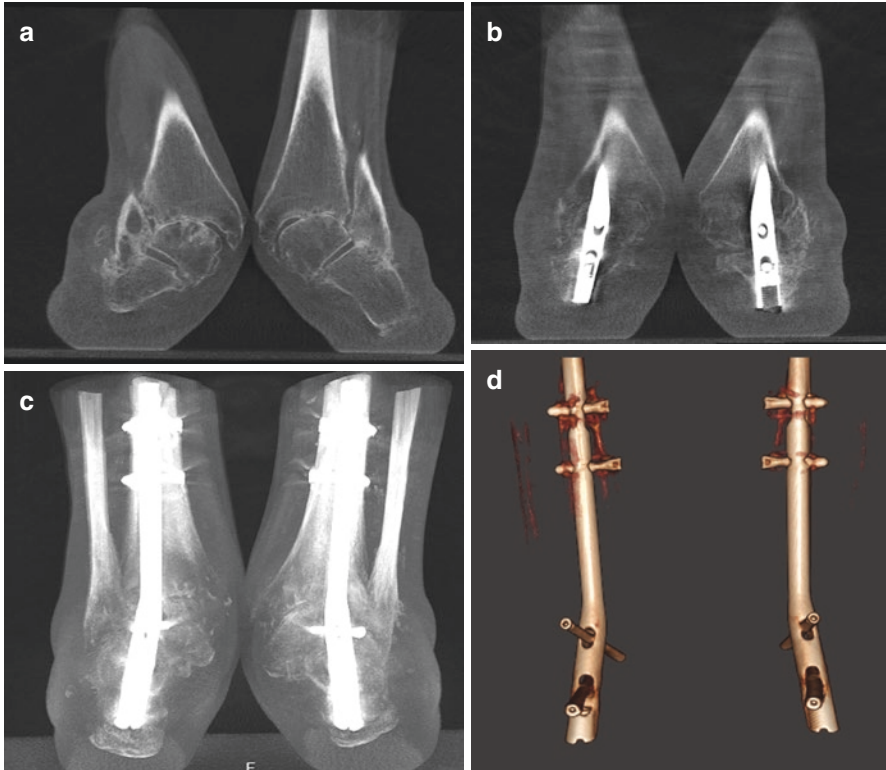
(a–d) Charcot arthropathy at the hindfoot (Localization Sanders IV) before (a) and after bilateral hindfoot correction arthrodesis (b–d). The preoperative paracoronal reformation (a) shows severe hindfoot valgus and destruction of ankle and subtalar joints. (b) shows a paracoronal reformation after bilateral hindfoot correction arthrodesis with retrograde arthrodesis nail (A3, Stryker, Kalamazoo, MI, USA). (c) shows a generated virtual hindfoot radiograph (so-called Saltzman view) showing the hindfoot axis and the entire implant. (d) shows a 3D reformation of the implants with best visibility of the locking screws
